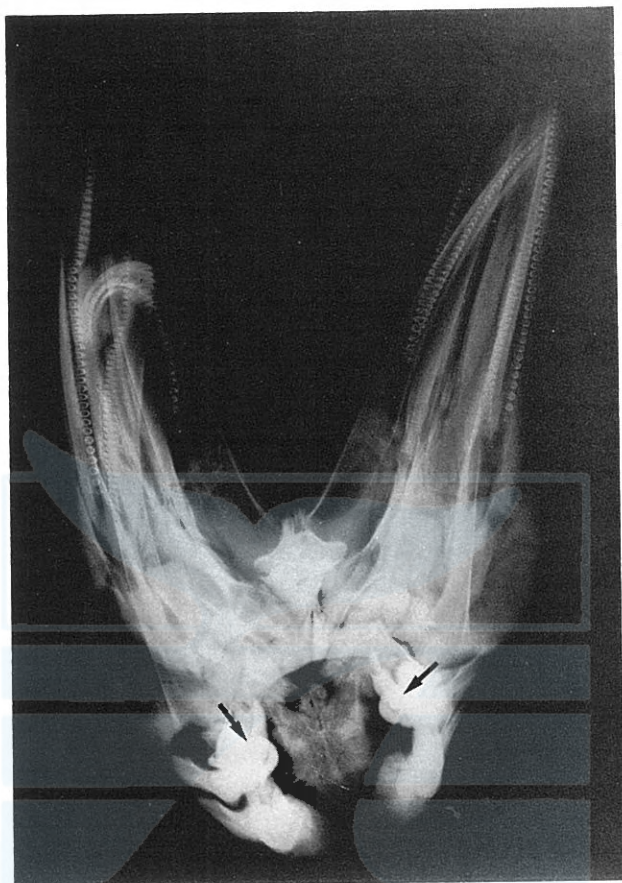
An X-ray photograph taken in dorso-ventral direction. Arrows show the petrous bones. It can be noted that the skull-cap is unformed.
